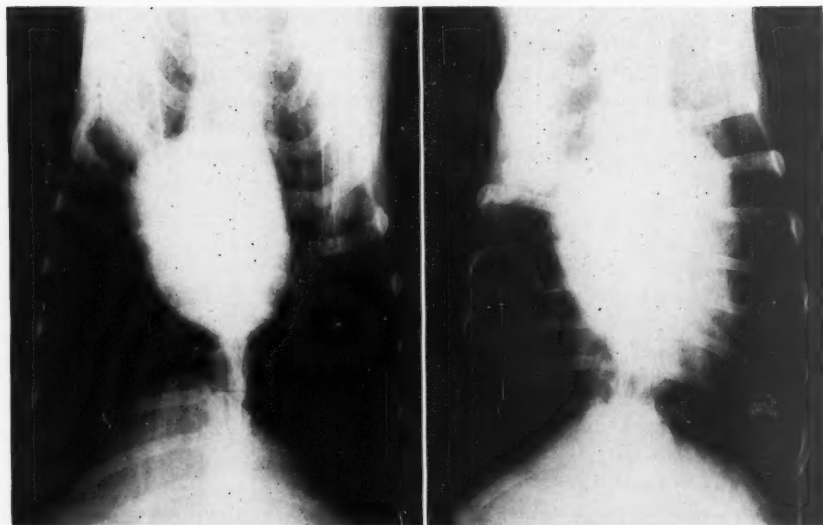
Two-meter chest x-ray films preoperatively (left), and 12 days after performance of surgical complete heart block (right). Preoperative rate was 120 per minute and idioventricular rate was 40 per minute. Note cardiac enlargement and pulmonary vascular congestion after block.
